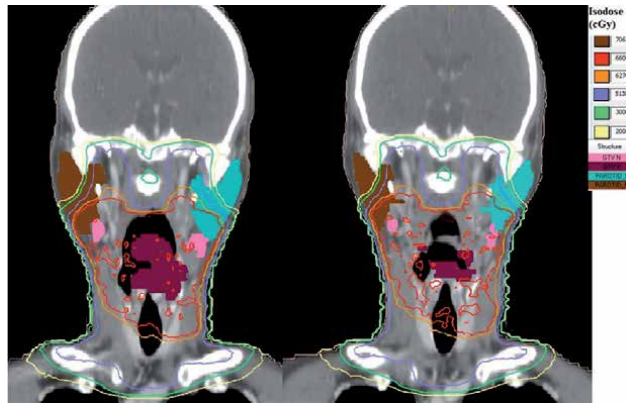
Comparison between pre-treatment (CT1) [left] and per-treatment (CT4) [right] images of a patient. Coronal CT slices of a 57 years old male patient with carcinoma hypopharynx (T4aN2c). The decrease in volume of GTV primary (maroon) [from 30.426 cc in CT 1 to 5.964 cc in CT 4] and GTV nodal (pink) [from 10.005 cc in CT 1 to 4.638 cc in CT 4] can be appreciated along with decrease in volume of both right (brown) and left (light blue) parotid glands.
